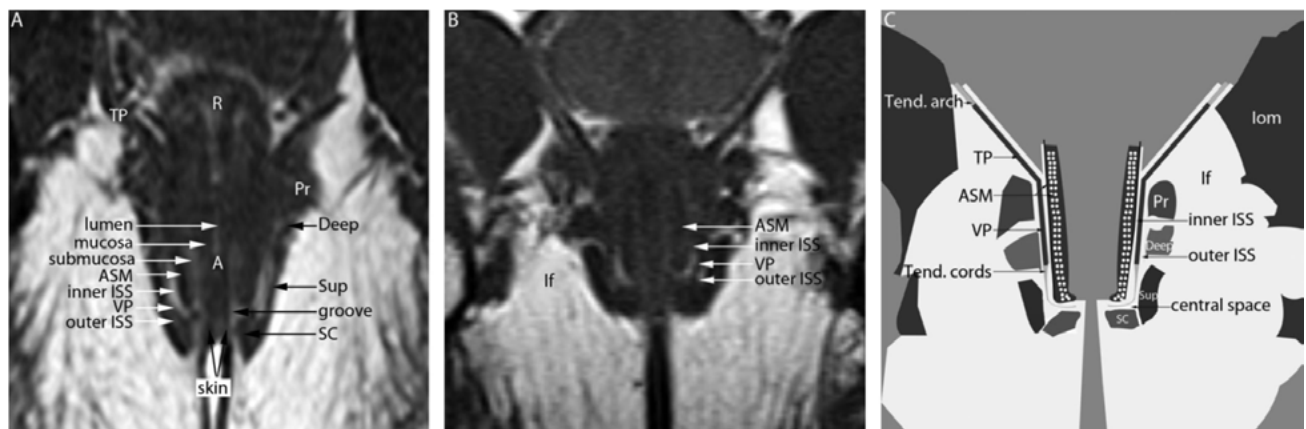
Midcoronal T1-weighted turbo spin-echo body coil MRI images (27).
